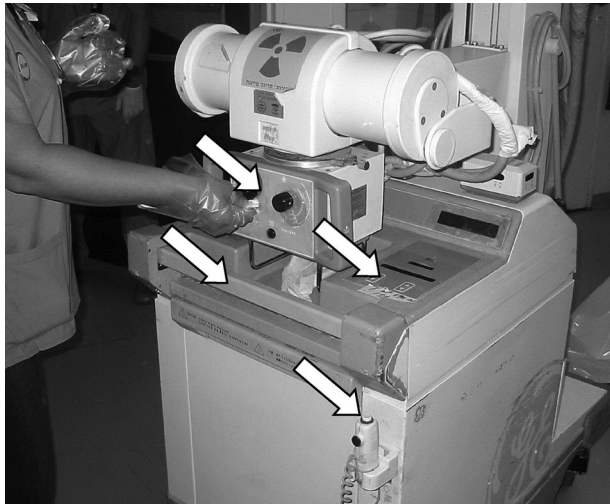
Areas of radiograph machine cultured (marked by arrows).
